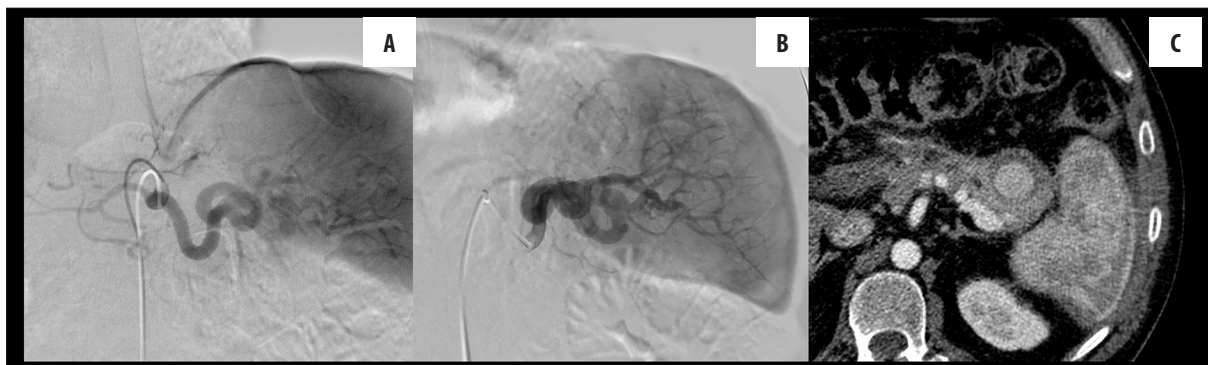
Selective angiography of the celiac trunk (A) and splenic artery (B) does not demonstrate the perfusion of the pseudoaneurysm. (C) CT scan performed immediately after the diagnostic angiography shows the persistence of the pseudoaneurysm.
